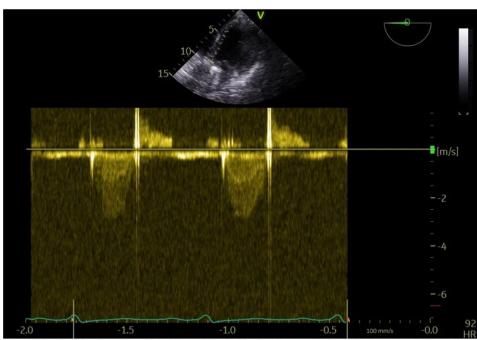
Spectral Doppler of the left ventricle outflow in the deep transgastric long axis view immediately post cardiopulmonary bypass after the obstructed mechanical aortic valve leaflet was repaired.
